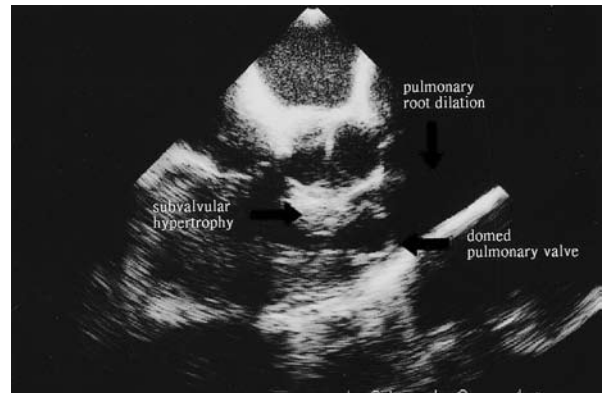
Transesophageal echocardiography revealed a domed pulmonary valve with slight subvalvular hypertrophy and pulmonary root dilation.
